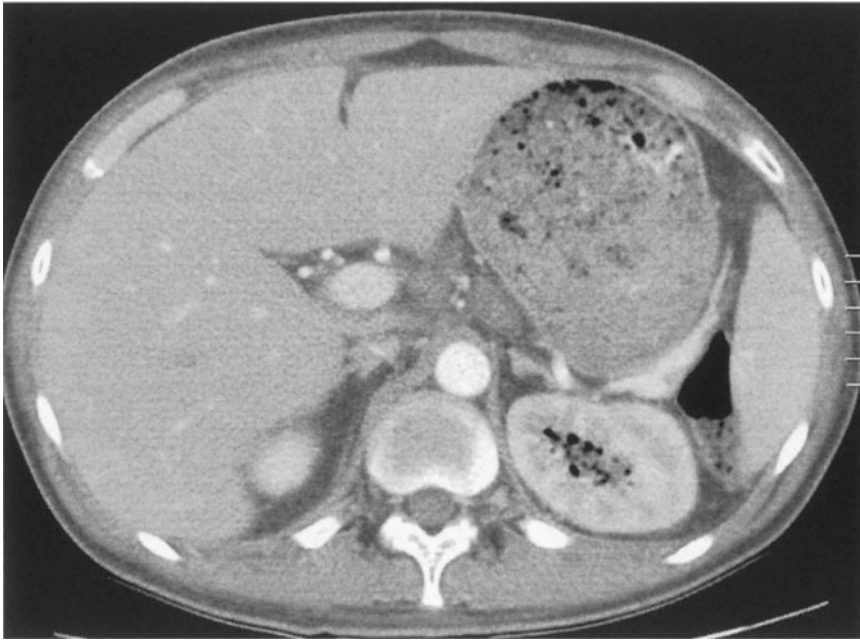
CT demonstrating gas within the left kidney. This diabetic patient had evidence of fungal pyelonephritis
